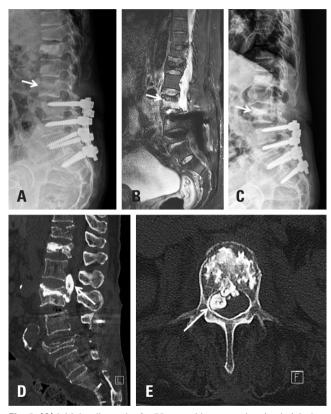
(A) Initial radiograph of a 79-year-old woman showing height loss at L2 (arrow). The patient had undergone vertebroplasty and spinal fusion 15 years ago due to a car accident. She had osteopenia (T-score: -1.4) at that time. (B) T2-weighted magnetic resonance imaging showing an acute fracture at L2 (arrow). (C) Postoperative radiograph shows cement injected at the L2 vertebral body (arrow). (D) Postoperative computed tomography shows cement leakage through the spinal canal at L1-L2 (arrow). (E) Axial image of leaked cement on the right side of spinal canal (arrow). The patient showed transient motor weakness of the right hip flexor with hypoesthesia of the right thigh. The symptom improved within a week, and the patient was discharged with an independent ambulatory status.
